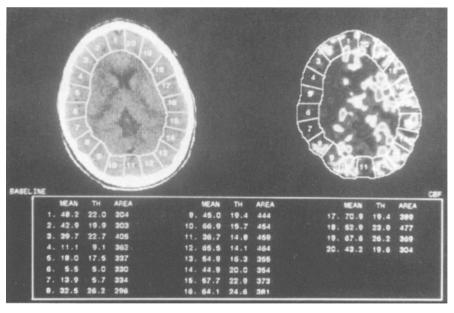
Xenon-CT demonstrating right MCA acute stroke with variable blood flow values. In this patient with acute stroke, the plain CT scan on the left is normal, while the CBF study with Xenon demonstrates the low flows in the right middle cerebral distribution. This quantitative technique demonstrates low flows in the regions of interest numbered 4 through 7, having CBF values ranging from 5.5 to 18.0 cc/100gm/min. At the lower values, the tissue is almost surely infarcted, while at the upper ranges, the tissue is probably viable
